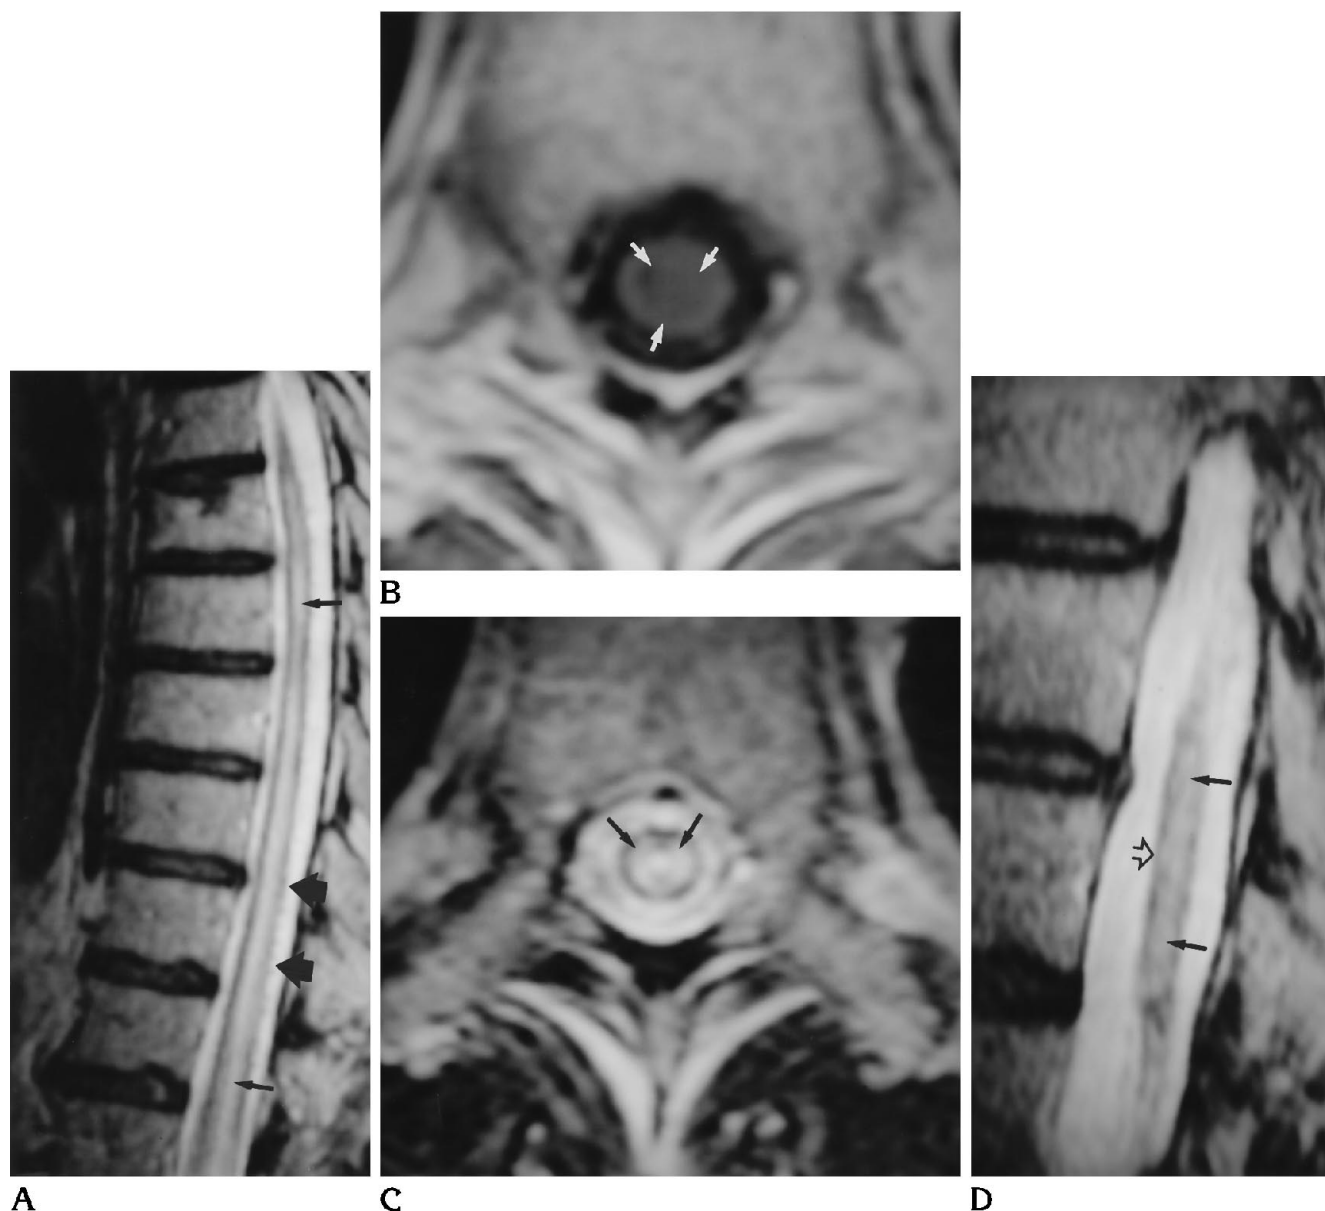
Case 6. A, T2-weighted sagittal thoracic MR shows subtle vessels on the dorsal aspect of the cord (*thick arrows*) and a diffuse intramedullary hyperintensity extending from the conus (*thin arrows*).
